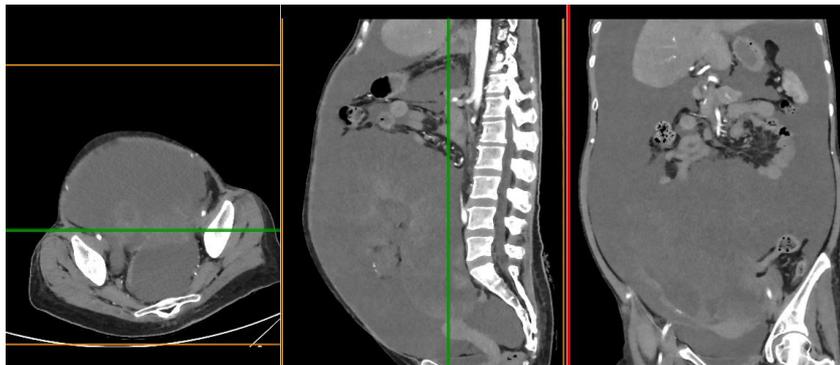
Serous carcinoma ovary, 24 y. o woman with CA 125 level 32.2 U/ml. CT scan feature showed cystic, with solid component, septic, irregular wall, contrast enhanced and ascites.
